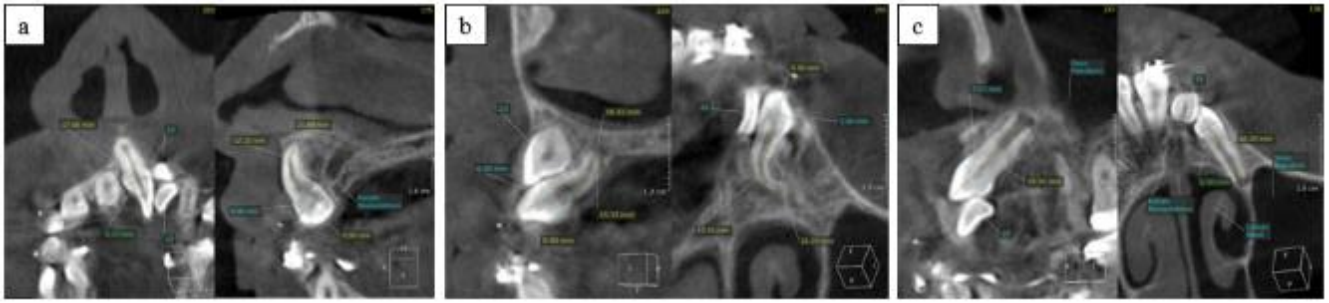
The multiplanar view of CBCT shows images of impacted teeth 21, 22, and 23 as well as deciduous teeth 63 with radiopaque images of orthodontic appliances along the occlusal line and palate
